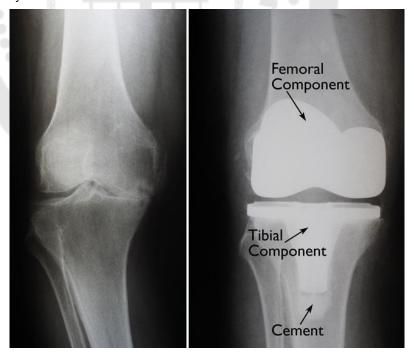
(Left) An x-ray of a severely knee osteoarthritis (Right)The x-ray appearance of a total knee arthroplasty.
